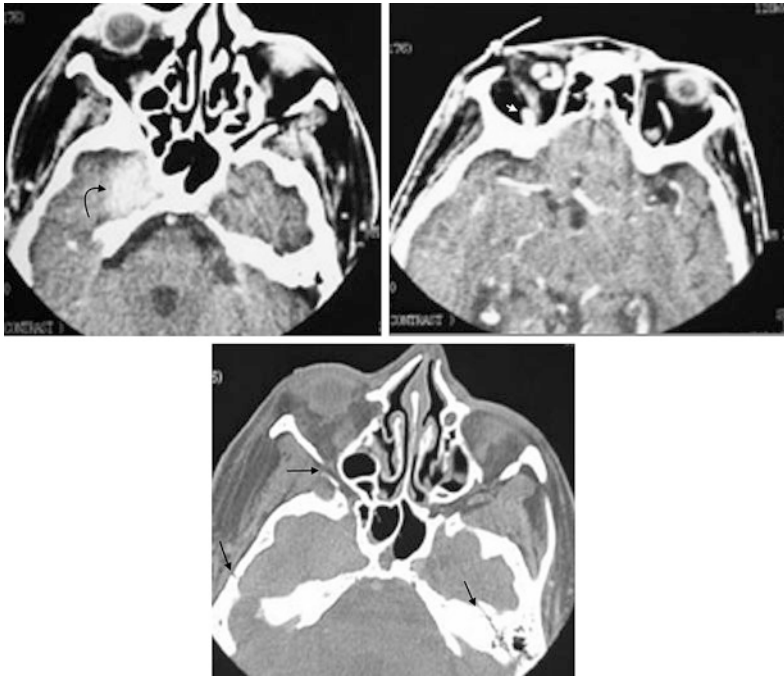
Traumatic CCF in a 29 years old male patient. a, b Post contrast axial CT image demonstrates enlargement of the right cavernous sinus (curved arrow) together with dilation and tortuosity of the right superior ophthalmic vein (arrow head). c axial CT in bone window demonstrates fractures of the right squamous temporal bone, right zygoma as well as left petrous bone (arrows)
